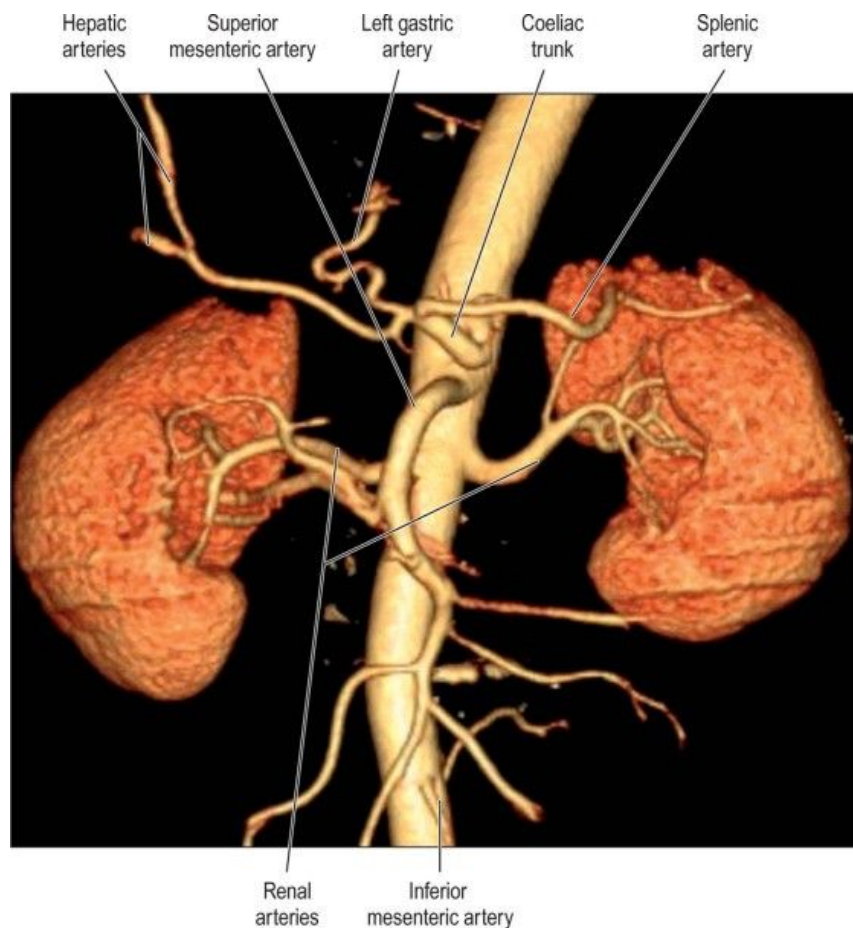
Volume rendered surface shaded CT angiogram of the major branches of the abdominal aorta (renal, coeliac and superior mesenteric arteries). (Courtesy of Dr Nasir Khan, Chelsea & Westminster Hospital, London.) (*Stadring et al., 2008*)
